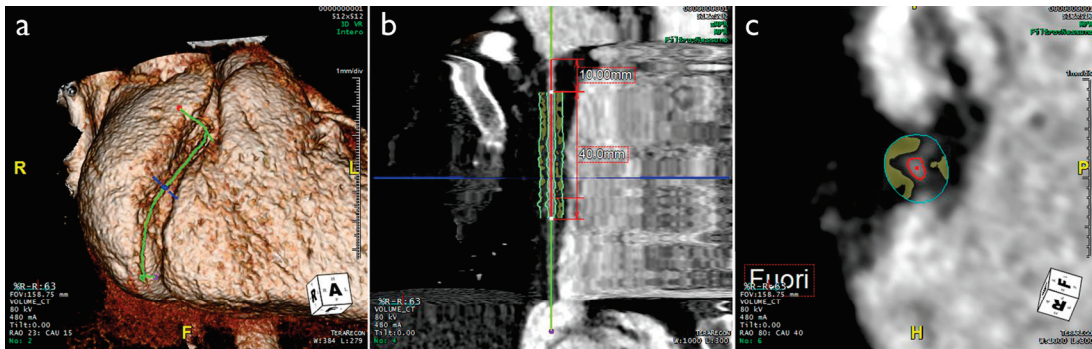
CT scan of a 39-year-old female patient. (a) 3D reconstruction of the heart, focusing on the middle segment of RCA. (b,c) PCAT distribution around RCA in longitudinal and orthogonal view, respectively (yellow spots). CT, computed tomography; PCAT, pericoronary adipose tissue; RCA, right coronary artery.
